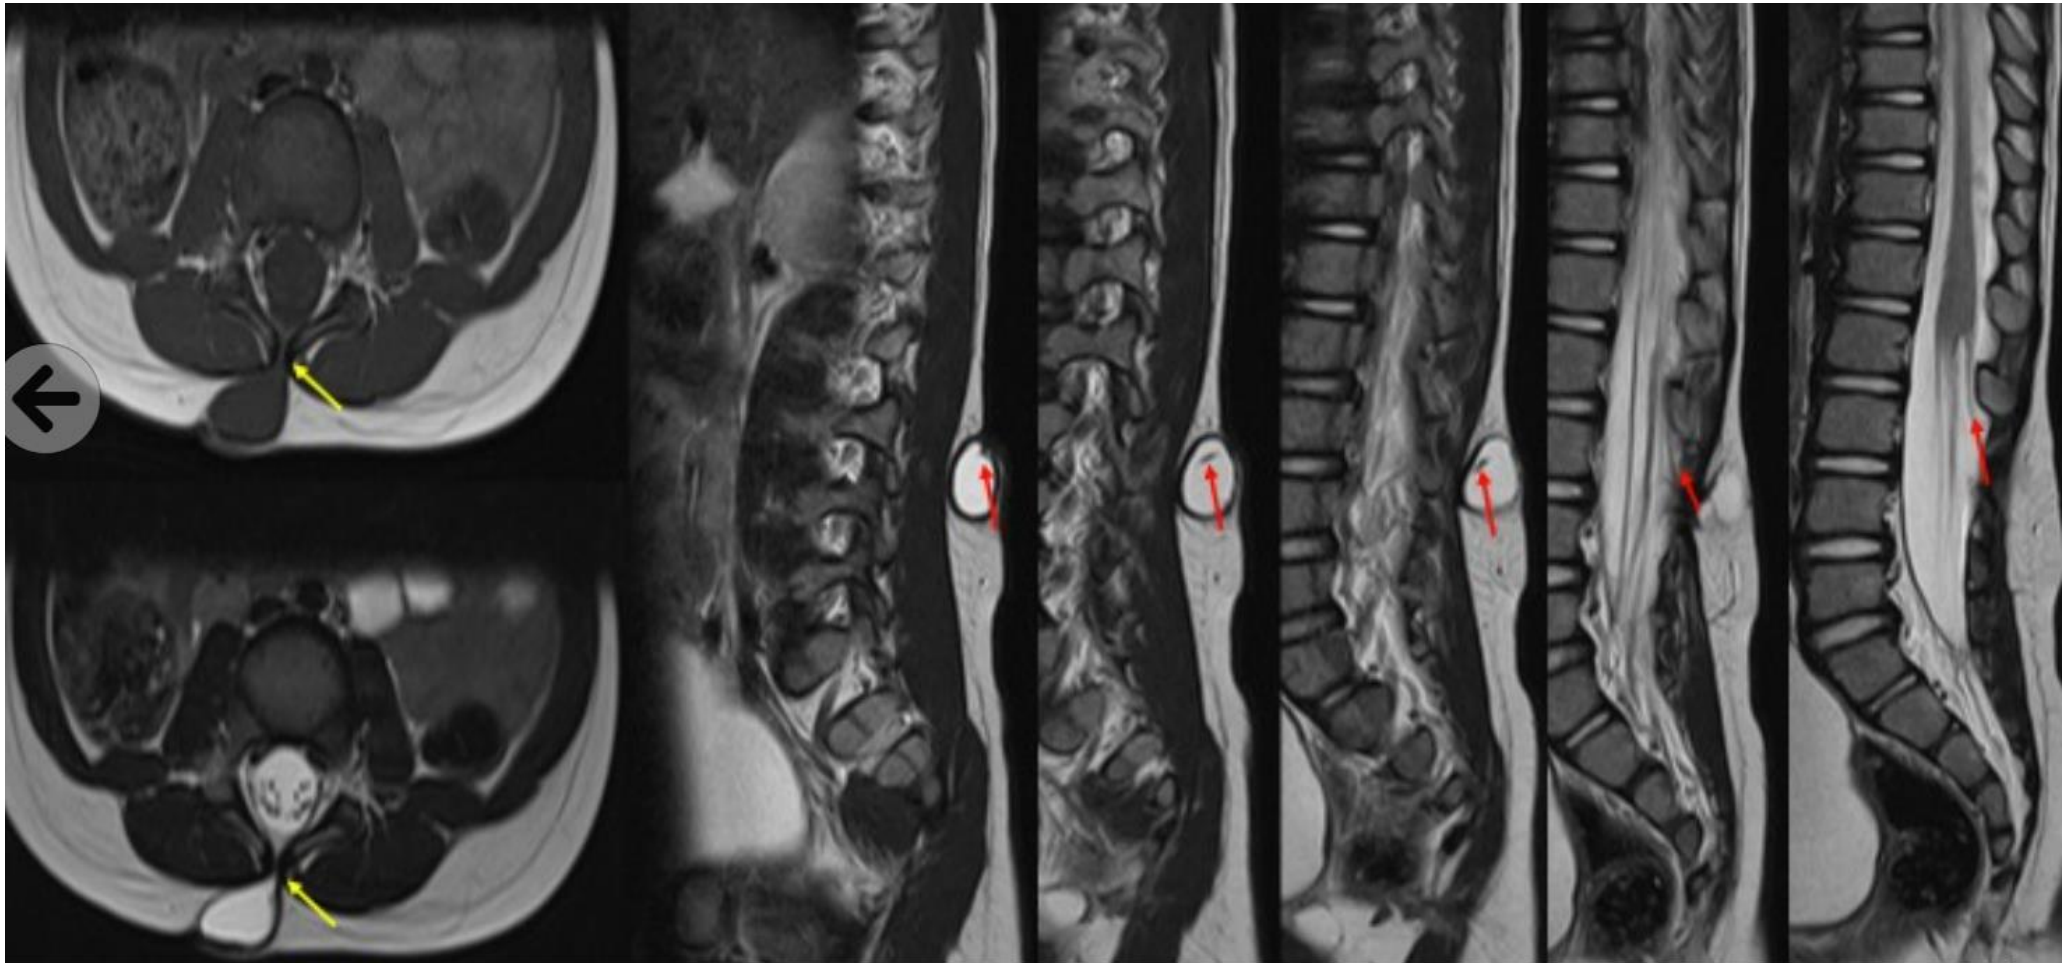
Saccular Limited dorsal myeloschisis: Axial images demonstrate a CSF signal intensity (yellow arrow) thin membranous sac. Serial Sagittal T2-weighted MR images show that the hypointense tract (red arrow) displaying a distinct hypointense round structure separate from the filum terminale or nerve roots is completely traceable in its entire course. The attachment site of the tract is the spinal cord just above the conus medullaris. A low-lying conus medullaris and dorsal tenting of the spinal cord at the tract-cord union are seen.
